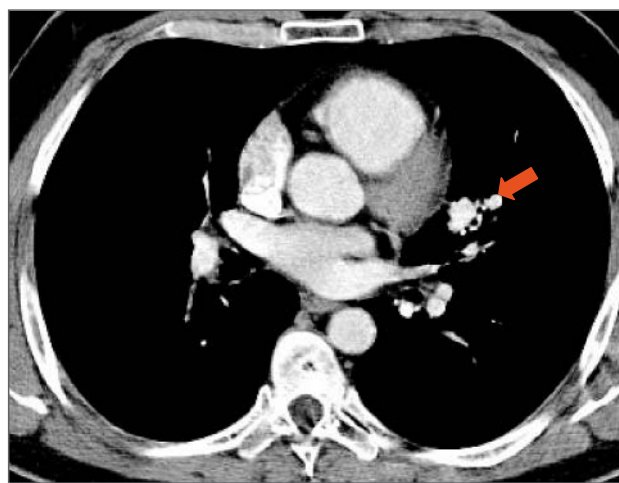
Axial multi-slice CT scan after intravenous contrast confirms a hypervascularized pulmonary AVM in the left upper pulmonary lobe (→).
